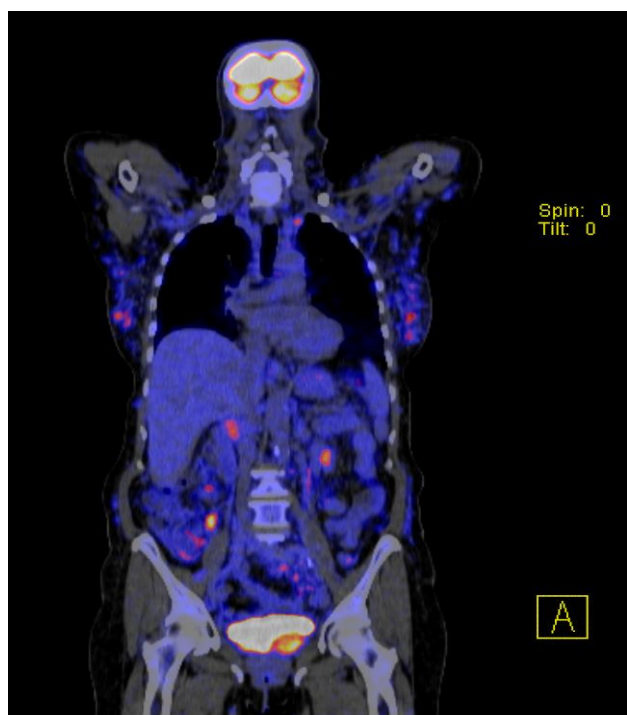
Fused PET CT images demonstrating abnormal activity on the breasts, with intraabdominal lesions and left hemi bladder mass.
